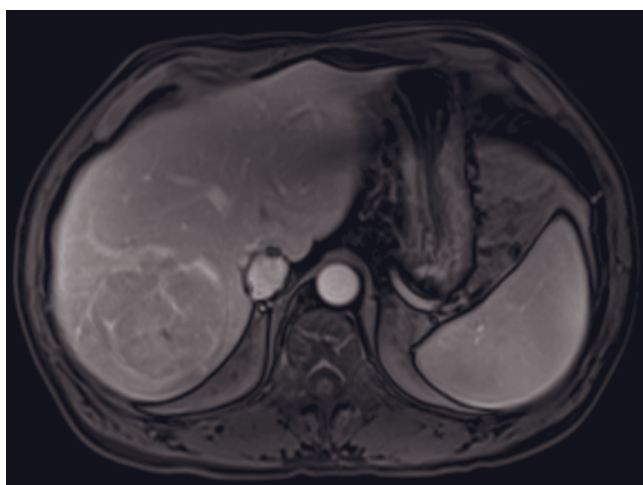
T2-weighted SS-ETSE (a), T1-weighted SGE (b), and immediate (c) and 90-s post gadolinium fat-suppressed (d) SGE images; immediate (e) and 90-s (f) postgadolinium fat-suppressed 3D gradient-echo at 3T demonstrate a large hyper-vascular HCC.
